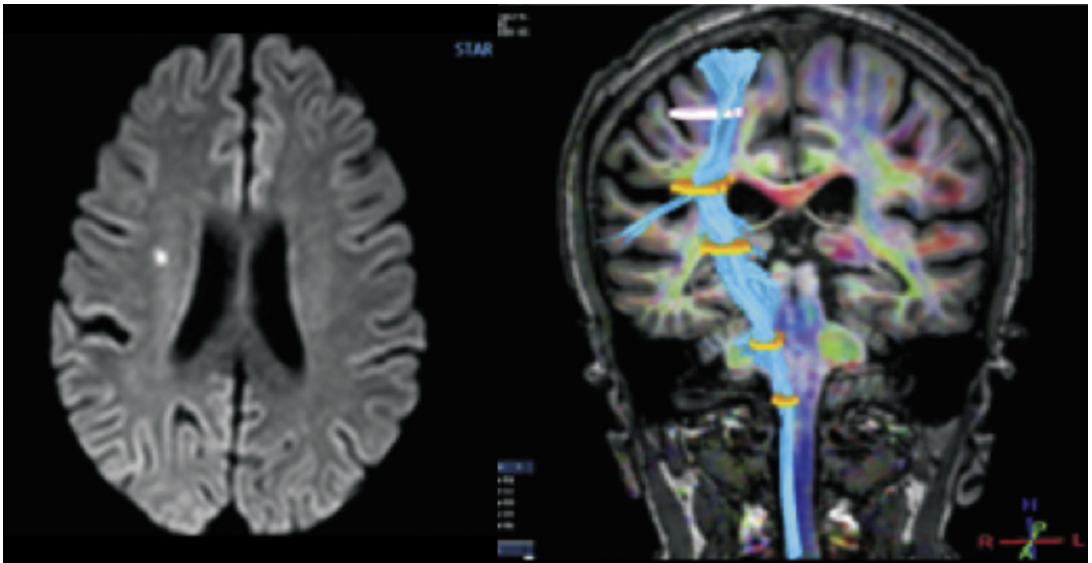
Uncrossed pyramidal tracts: a previously normal young adult with acute weakness on the right side and focal-diffusion-restricted lesion in the right corticospinal tract. Weakness on the same side was well explained with diffusion tractography (coronal postprocessed tractography superimposed on T1-weighted image), which showed that most of the right-sided fibers were continuing down the same side below the level of the medulla. This patient did not have scoliosis or lateral gaze palsy, a syndrome that has been well described with uncrossed pyramidal tracts. (Courtesy of Ashish Atre, MD, STAR Imaging Center, Pune, India).
